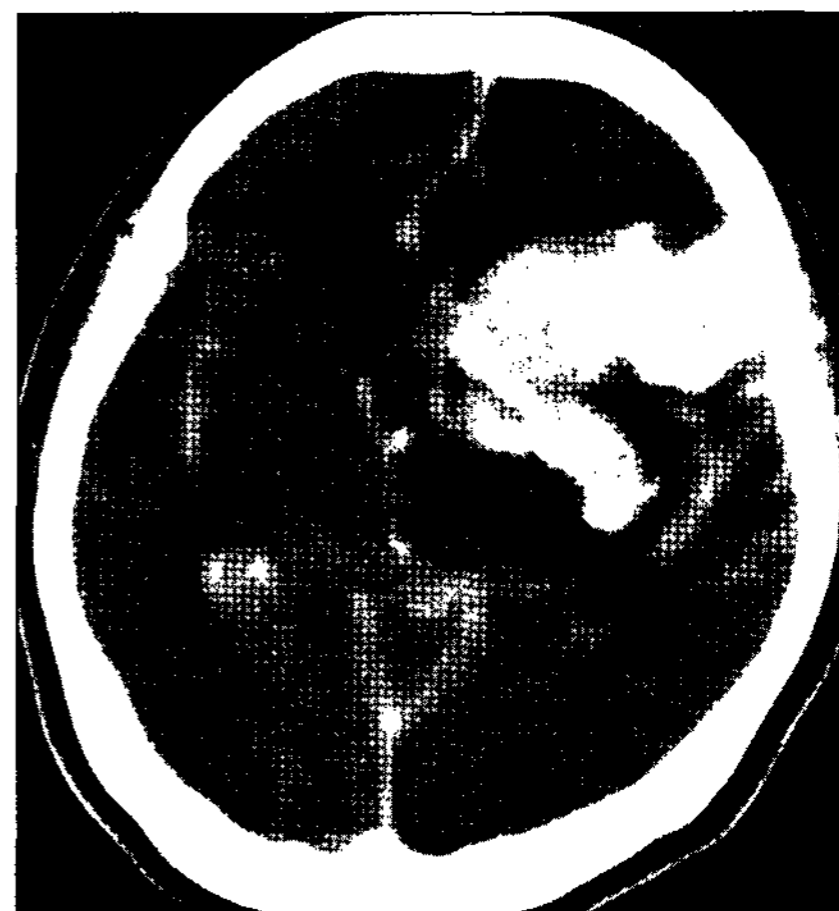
Postangiography brain computed tomograph. Brain computed tomograph revealing an increased a hematoma in the left basal ganglia and extravasation of contrast media into site of the intracerebral hemorrhage after cerebral angiography.
